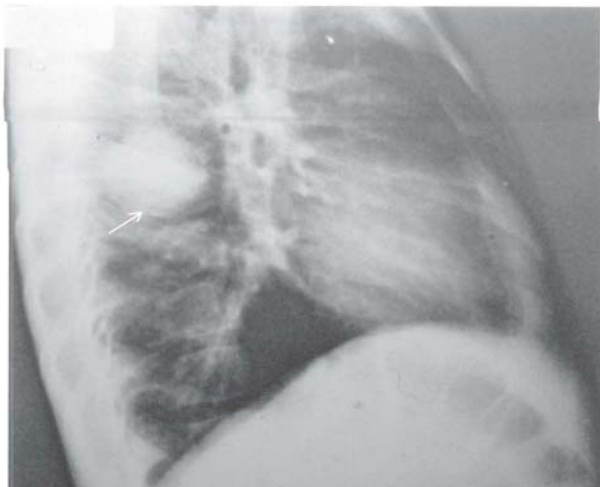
Lateral chest radiograph reveals a homogenous, smoothly marginated, 3-cm round lesion (arrow) in the right middle zone
